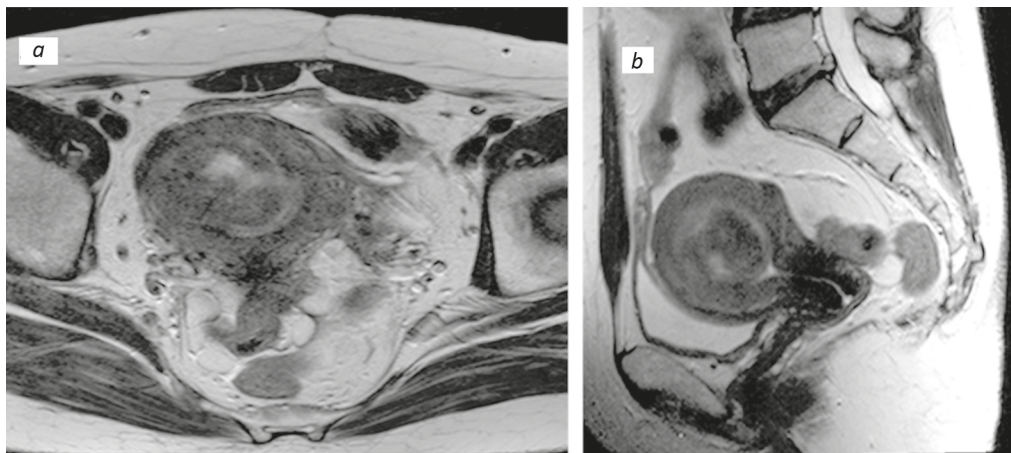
MRI of the woman's pelvis (a) axial projection, (b) sagittal projection. Submucous myomatous nodule
